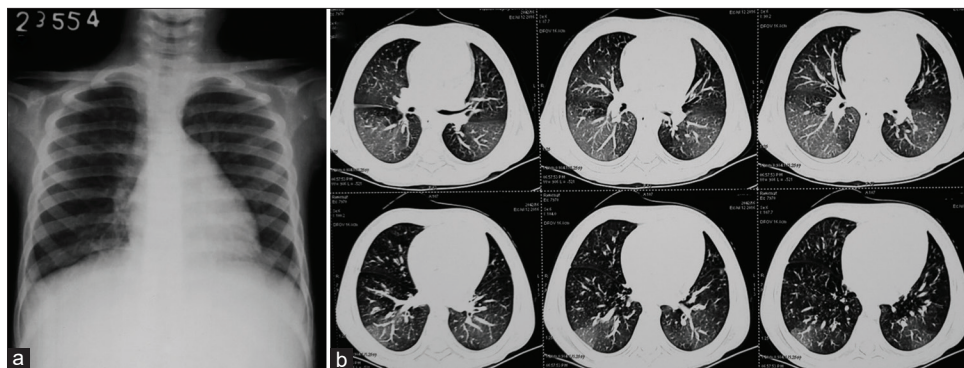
Chest X-ray and computed tomography chest of case 4: (a) Chest x-ray showing hyperinflation, (b) computed tomography chest is showing mosaic attenuation and centrilobular nodules
